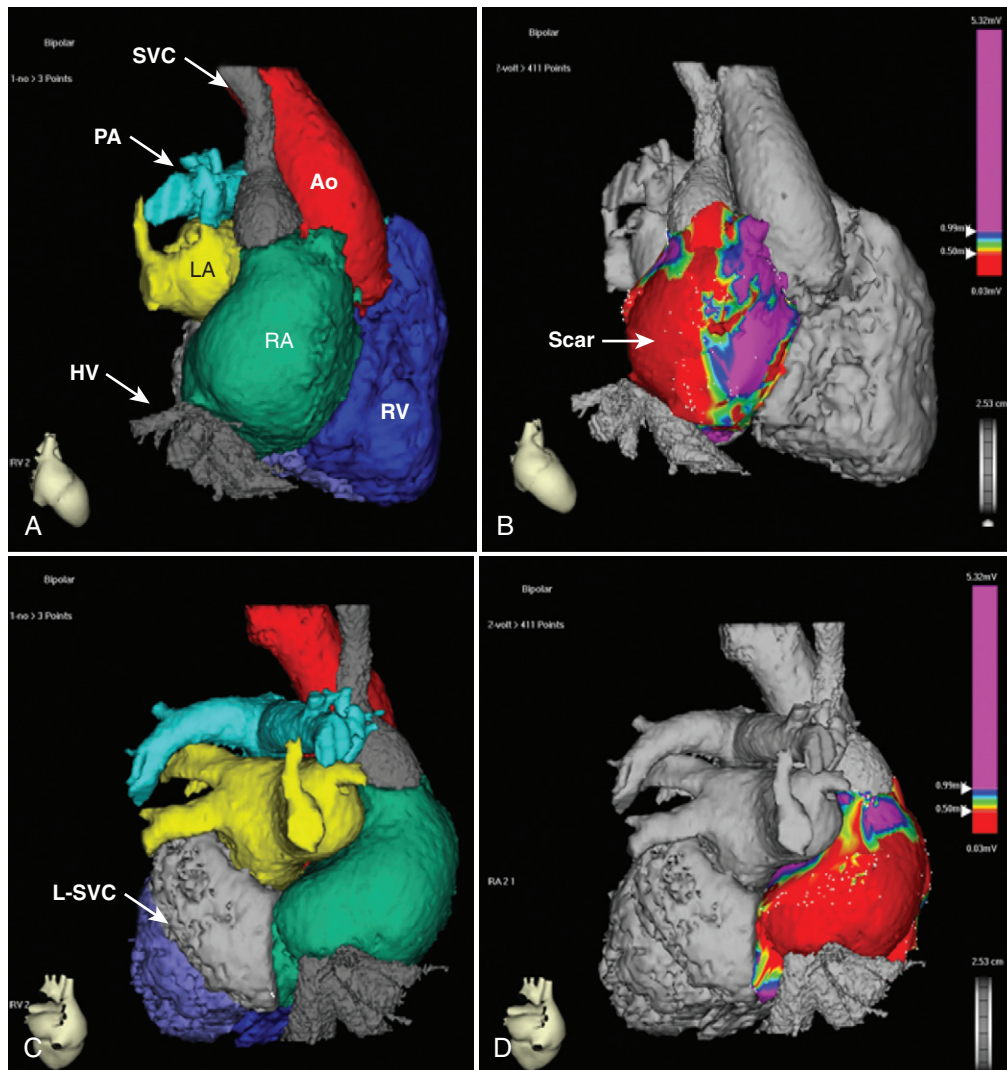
Electroanatomic map registered with a computed tomographic (CT) image in a patient who had incessant atrial tachycardia and double-outlet right ventricle (RV) repair, persistent left superior vena cava (L-SVC) interruption, and prior inferior vena cava interruption. A, Right lateral projection of the CT scan. Note the diminutive right-sided SVC and network of hepatic veins (HV) draining into the posterior right atrium (RA). B, Right lateral projection of bipolar voltage map projected onto the CT anatomy. An extensive area of posterolateral low voltage is depicted in red. C, Posteroanterior view of the CT anatomy showing the presence of a large persistent left L-SVC emptying into the CS. D, Posteroanterior view of the bi-polar voltage map. PA, Pulmonary artery; Ao, aorta; LA, left atrium.
